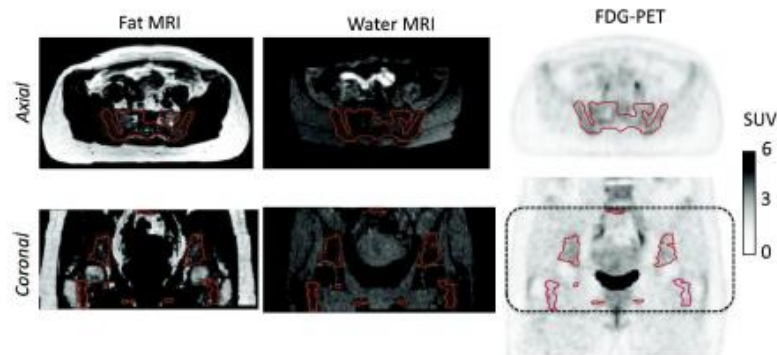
The segmented RBM regions (red contours) superimposed on fat/water MR and FDG-PET images are shown on axial and coronal planes. The dashed rectangle in PET image outlines the field of view of the MR images.
